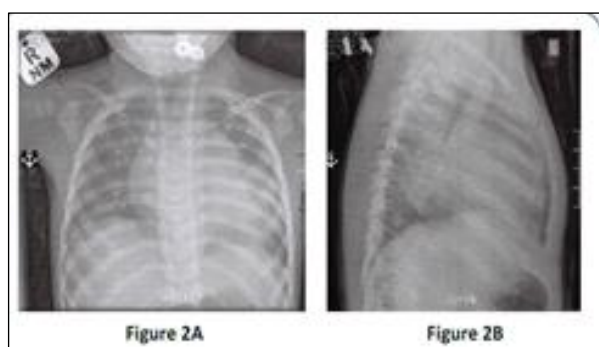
Chest radiograph showed significant cardiomegaly. Seven month old male with history of pompe disease with significant cardiomegaly and a cardiothoracic ratio measuring 67% and multi-Chamber prominence.
